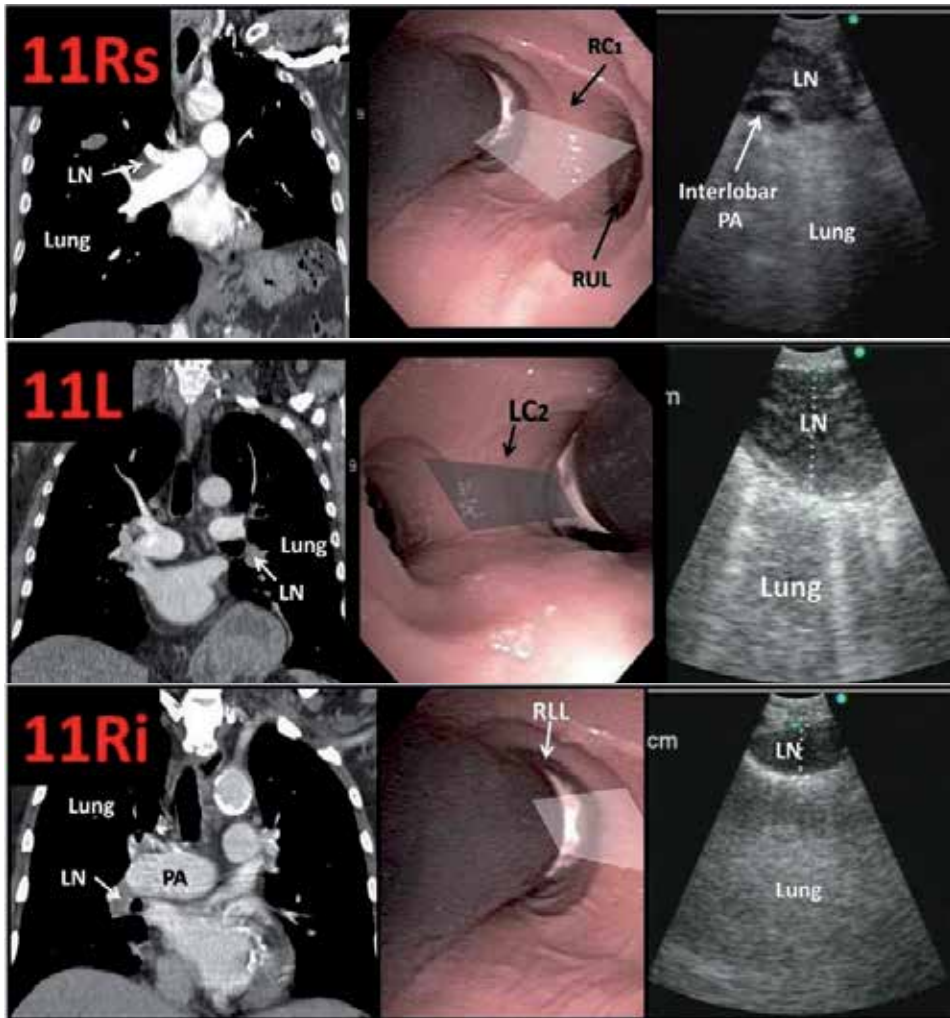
Station 11 lymph nodes (hilar nodes): Sagittal CT, endoscopic view and corresponding EBUS [106]. Courtesy of Septimiu Murgu, MD and Henri Colt, MD; Bronchoscopy International www.bronchoscopy.org
